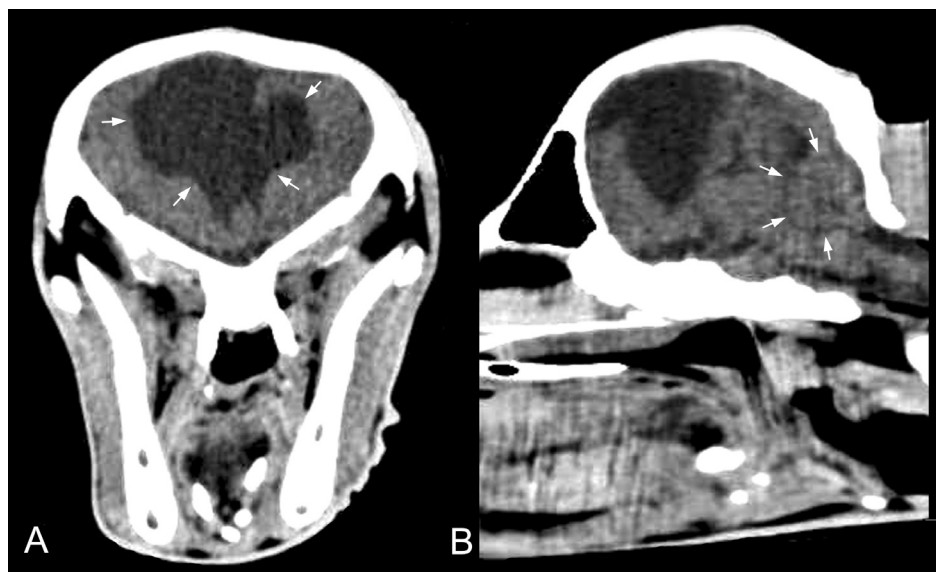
Non-contrast transverse (A) and sagittal (B) computed tomographic images of the brain. Bilateral ventriculomegaly and a cyst-like lesion (A, arrows) communicating with the right lateral ventricle are observed. Note the absence of the septum pellucidum. The cerebellum is decreased in size (B, arrows)
